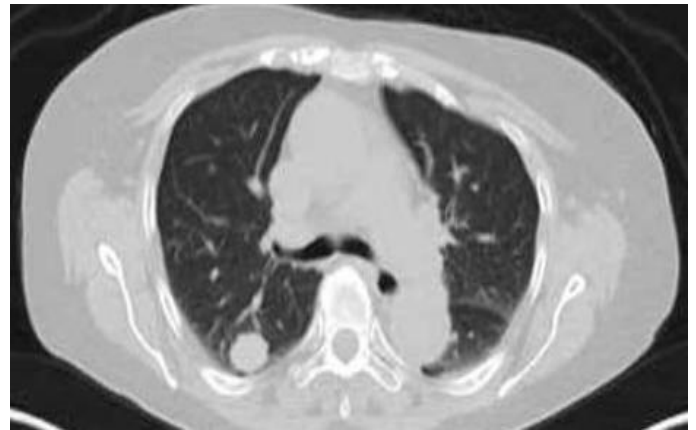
Preoperative computed tomography of the chest. Right upper lobe nodule with a smooth outline.
